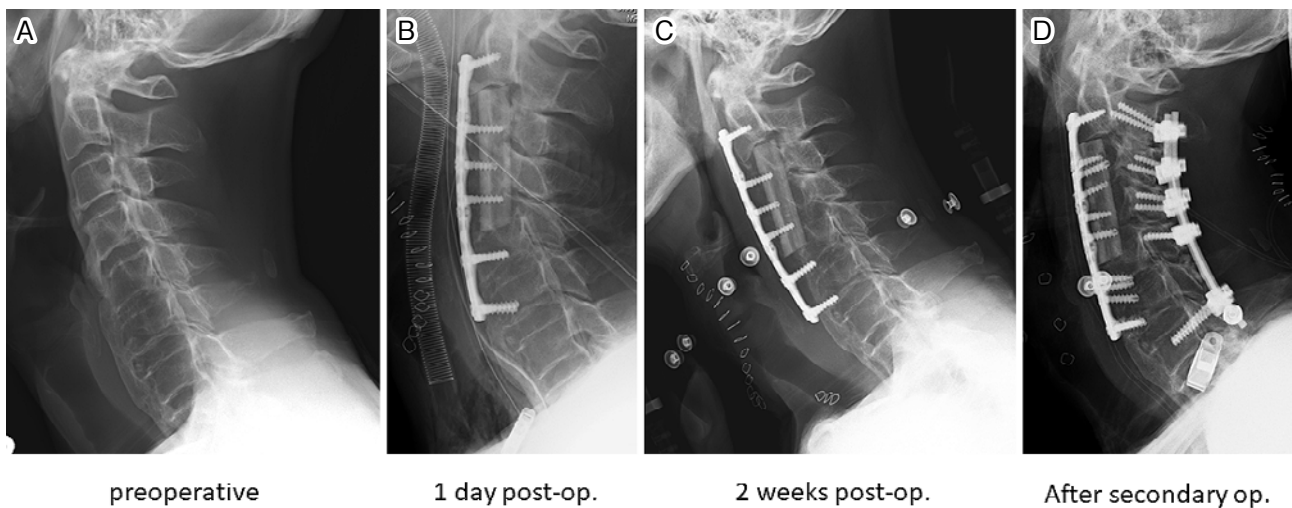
A. Preoperative lateral radiograph showing a C2-7 angle of 8.3 degrees, FSA of 6 degrees, and FSH of 72.4 mm. B. Lateral radiograph taken immediately after surgery showing that the C2-7 angle increased to 34.3 degrees, FSA to 29.8 degrees, and FSH to 96.1 mm. C. Graft dislodgement at 2 weeks after the index surgery. D. A second anterior procedure was performed to optimize the graft placement. Posterior fixation was added to stabilize the structure.
